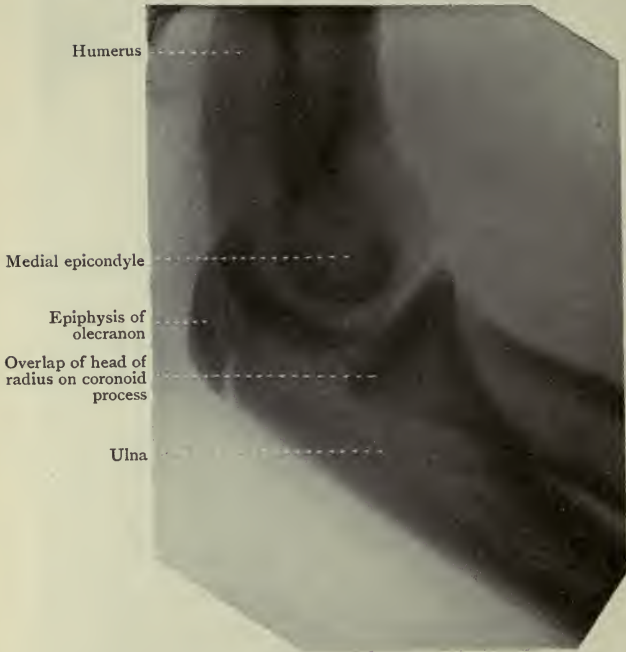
Lateral Radiograph of a partly bent Elbow Joint, showing Epiphysis of Olecranon.
